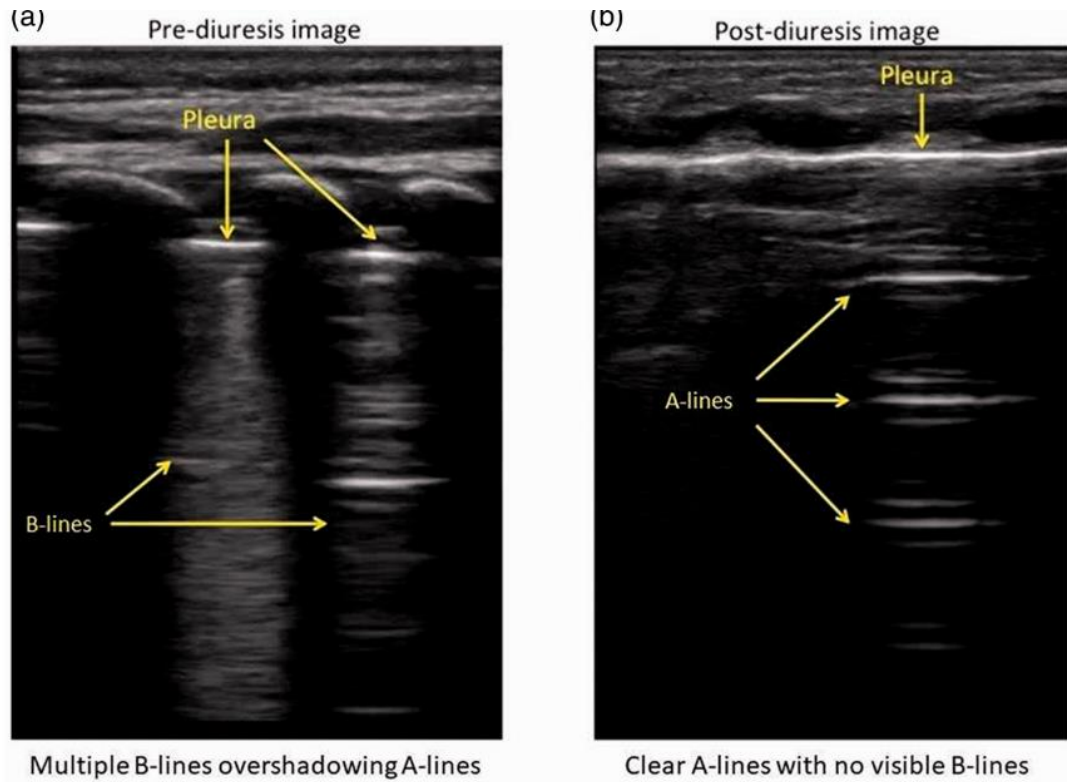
Conventional bedside lung ultrasound for assessment of pulmonary edema in a 9-week-old baby.⁷⁸
